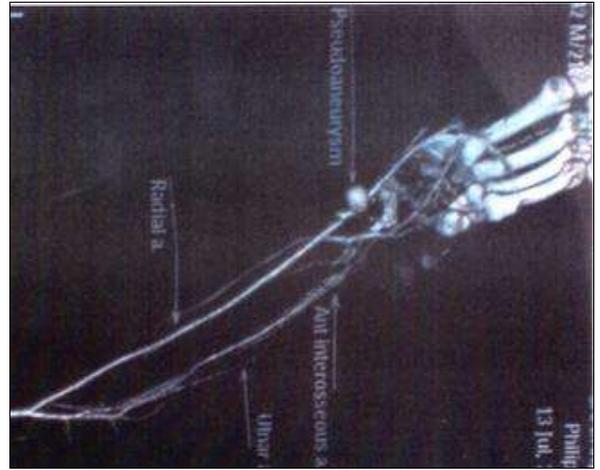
CT Angiography showing radial artery pseudo aneurysm at electric contact site
